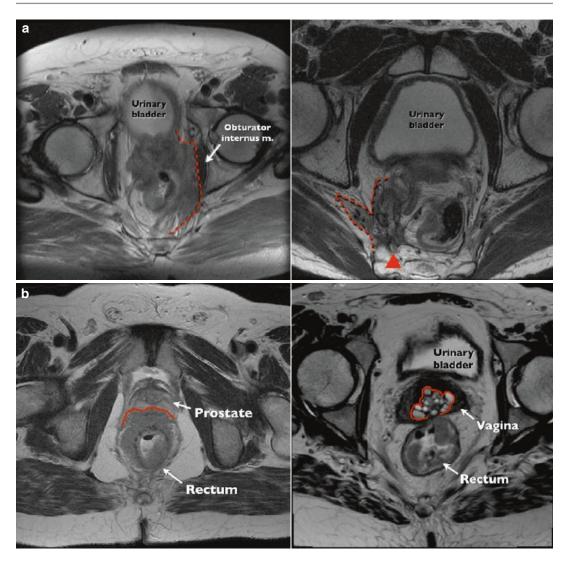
(a) Examples of magnetic resonance imaging (MRI) demonstrate tumors that are not suitable for the robotic approach with regard to invasion into the lateral compartment (red broken line) and sacral nerve root (red
